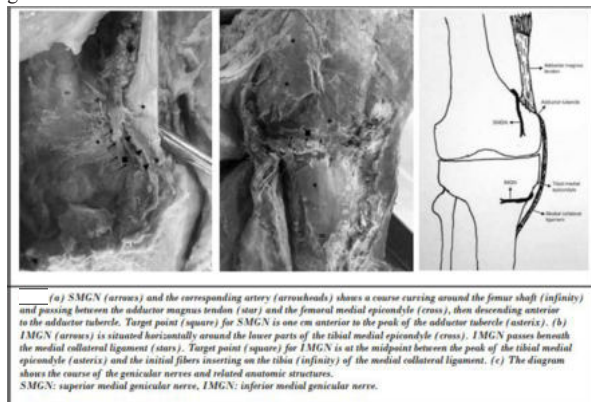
4 showing Nerve supply of knee joint, nerve course and target point⁵ (Yasar E, et al. Accuracy of Ultrasound-Guided Genicular Nerve Block: A Cadaveric Study. Pain Physician. 2015;18(5):E899-904.)
